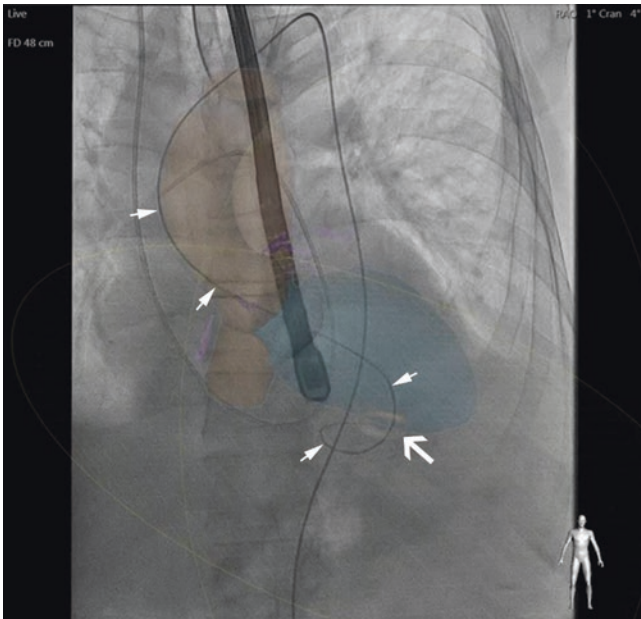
CTA-fluoroscopy fusion—crossing ventricular septal defect. Fusion of the CTA with live fluoroscopy shows a 3D model of the heart overlaid over the fluoroscopy during the procedure for guidance. Segmentation of the heart is visible, but it is dimmed to avoid blocking the view of the wires. A circular marker at the position of the ventricular septal defect (VSD) helps the operator in steering the guidewire. The guidewire (small white arrows) is seen crossing the ventricular septal defect (VSD) retrograde from the aorta. The guidewire is inserted into the right ventricle through the VSD (large white arrow)
